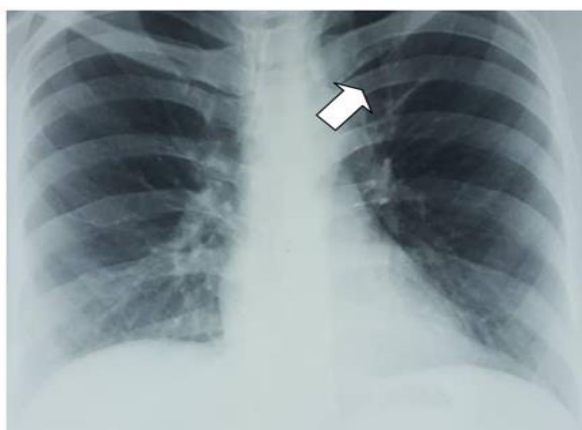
Chest Radiography after treatment with steroid
